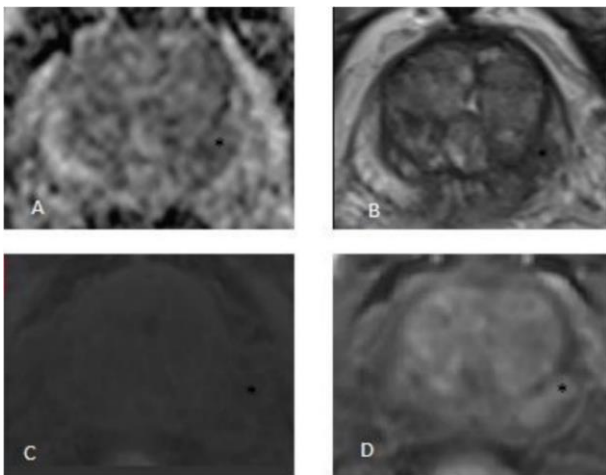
PI-RADS 4 lesion. Prostate MRI of a 66-year-old patient with Gleason score 7 (4+3). A) ADC, B) axial T2W, C) axial T1W with fat suppression, D) DCE (Dynamic Contrast Enhanced) sequences. Peripheral zone 8*13mm lesion (asterisk) with low T2 signal intensity showing contrast enhancement and restricted diffusion with low ADC signal
